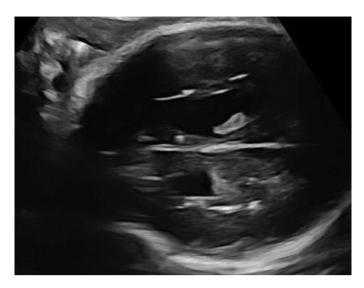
Fetal toxoplasmosis - intracranial ultrasonographic findings
